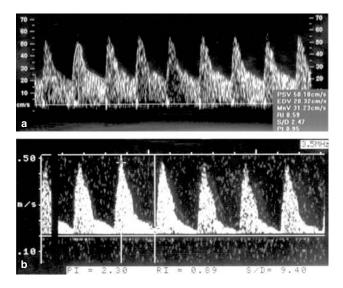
Pulsed Doppler waveforms from the middle cerebral artery of a 35-week growth-restricted twin (a) with enhanced diastolic flow and a normally grown twin at 34 weeks' gestation with normal pattern of blood flow (b)
